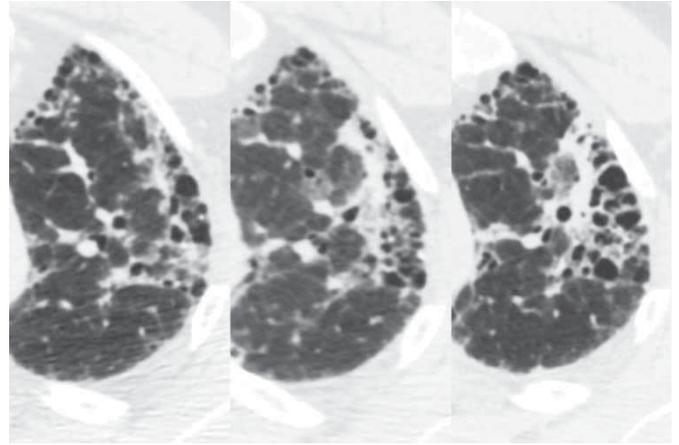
Evaluation of complications. Lung cancer in the setting of idiopathic pulmonary fibrosis. Baseline high-resolution computed tomography (left) shows a usual interstitial pneumonia pattern of fibrosis. A follow-up scan performed 9 months later (centre) shows a new, subtle band of ground glass and consolidation in the left upper lobe. A short-term follow up was performed 3 months later (right), which showed slight enlargement of the abnormality, and this was subsequently proven to represent lung adenocarcinoma.
